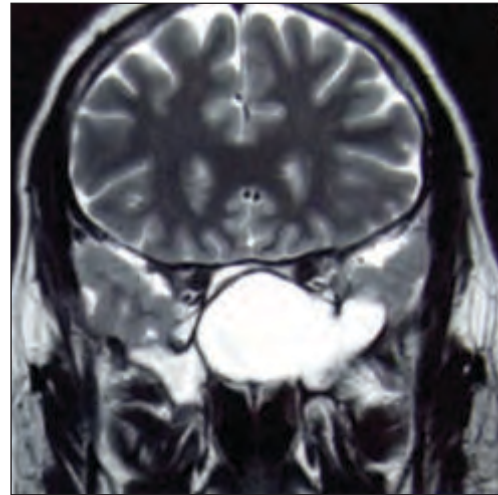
MRI Coronal View T2 weighted image showing mucocele in sphenoid
